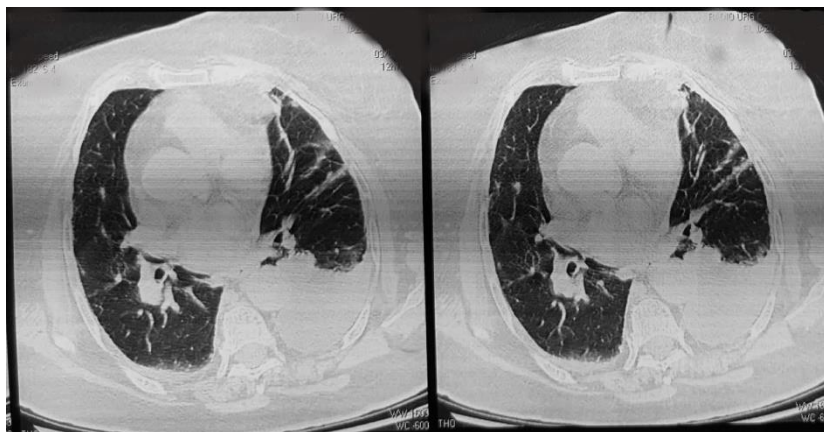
Chest CT scan showing, Ground glass opacities, crazy paving images, multiple pulmonary nodes, bilateral pleural effusion (more abundant on the left).
